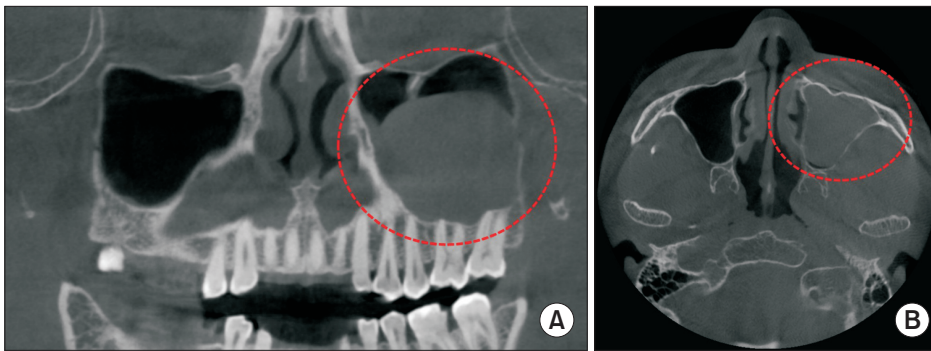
Cone beam computed tomography image obtained after the pain recurrence. The dotted circles show mucosal thickening in the left maxillary sinus. (A) Coronal view. (B) Axial view.
